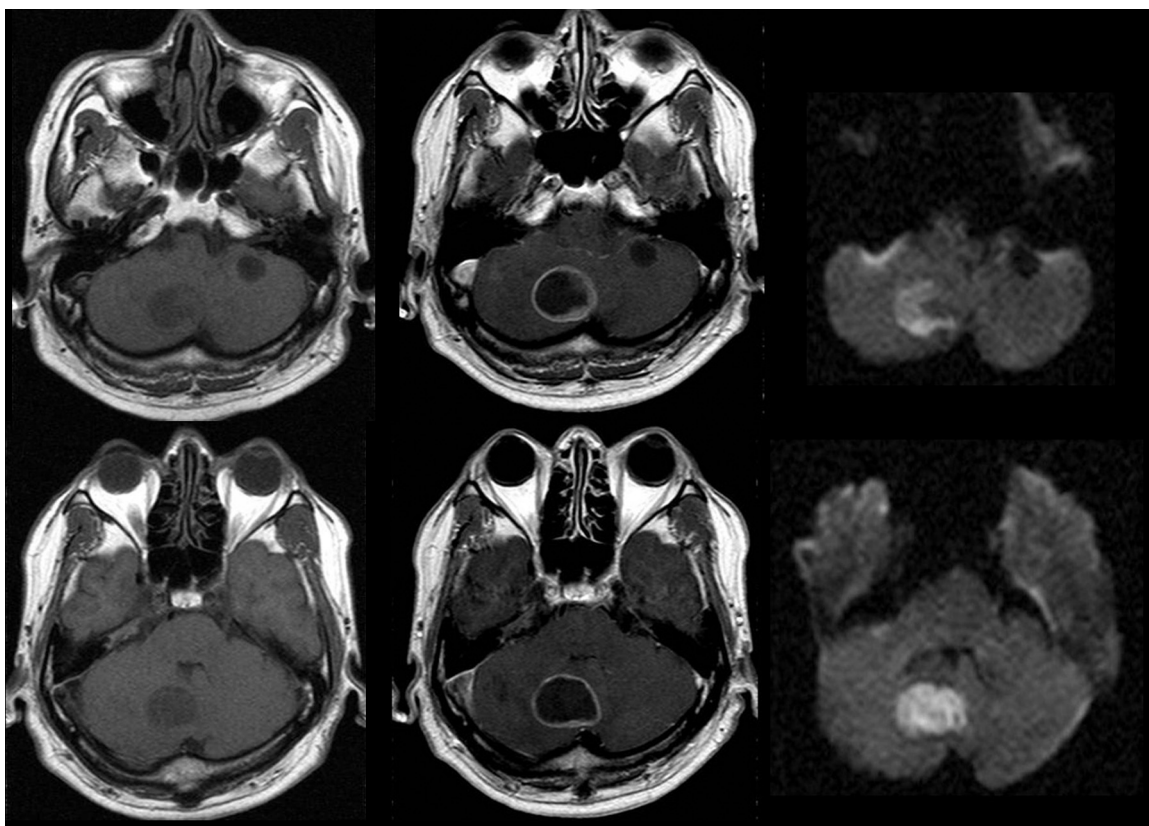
MR images on admission demonstrating two different types of lesions in each cerebellar hemisphere. The right lesion shows ring enhancement with gadolinium and hyper-intensity on DWI, whereas, the left lesion does not. Left: T1-weighted images, center: T1-weighted images with gadolinium, right: diffusion-weighted images.
